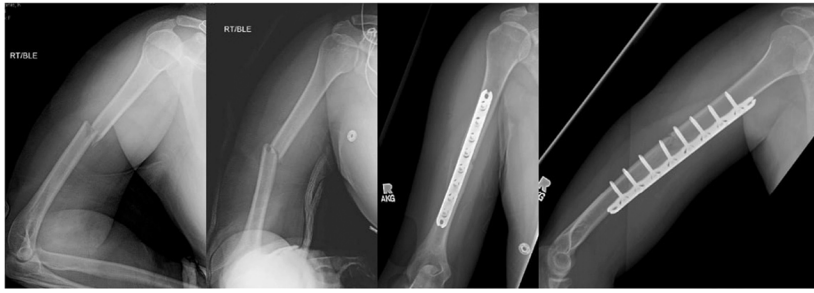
X-ray of initial fracture and two-month follow-up after primary open reduction and internal fixation.
